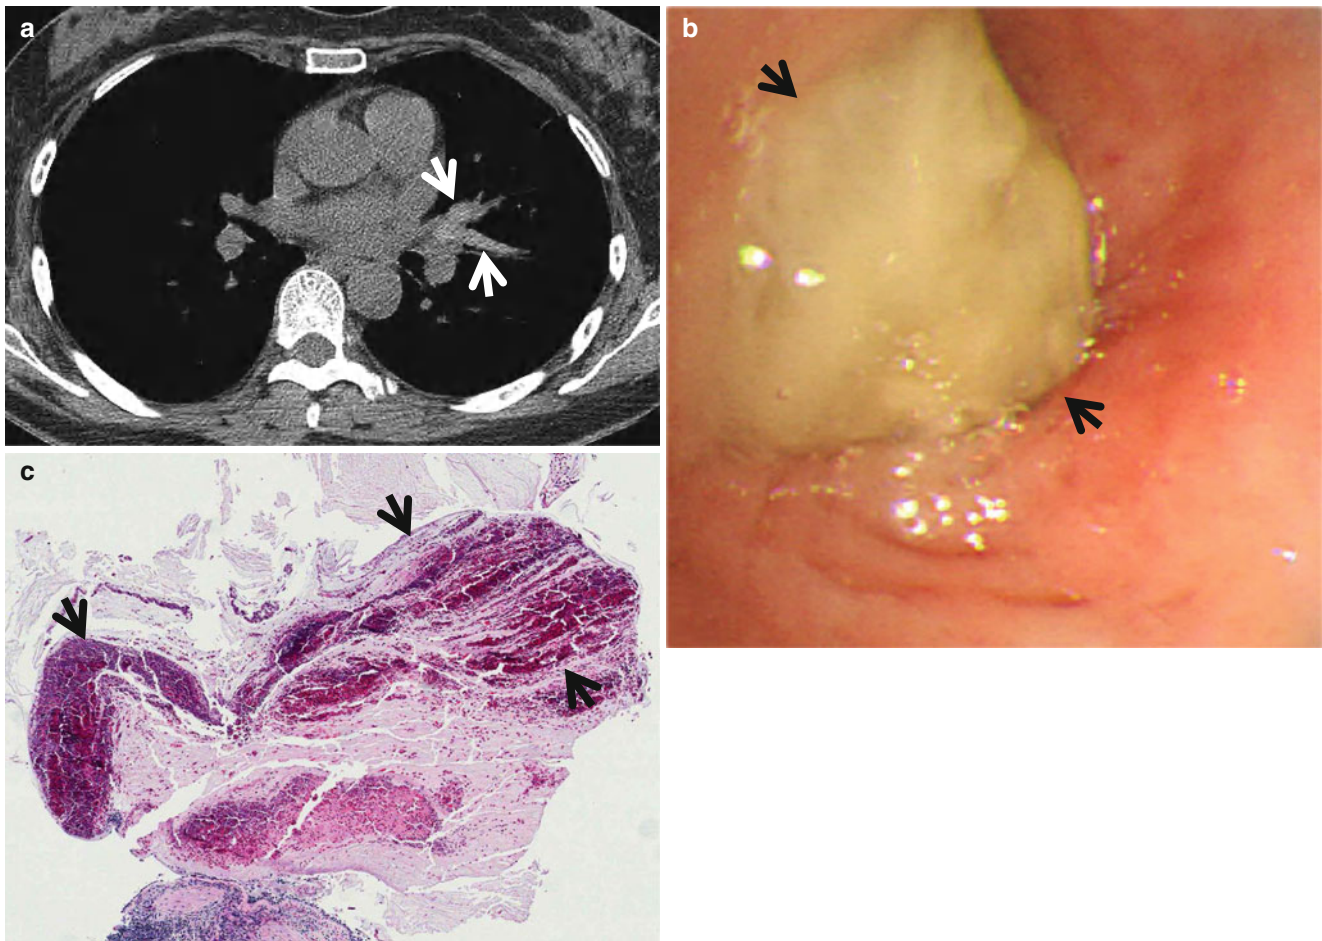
Allergic bronchopulmonary aspergillosis in a 56-year-old asthmatic woman. (a) Mediastinal window of unenhanced CT scan (2.5-mm section thickness) obtained at level of the right middle lobar bronchus shows high-attenuation V-shaped branching structures (arrows) in lingular division of the left upper lobe. (b) Bronchoscopy
